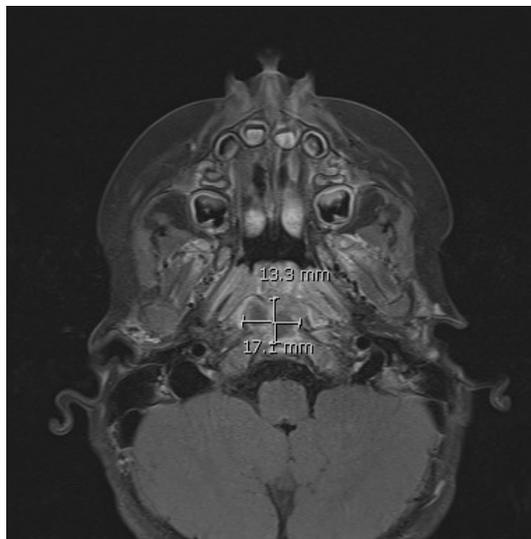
Axial T2 MRI head demonstrating clival multiloculated collection
